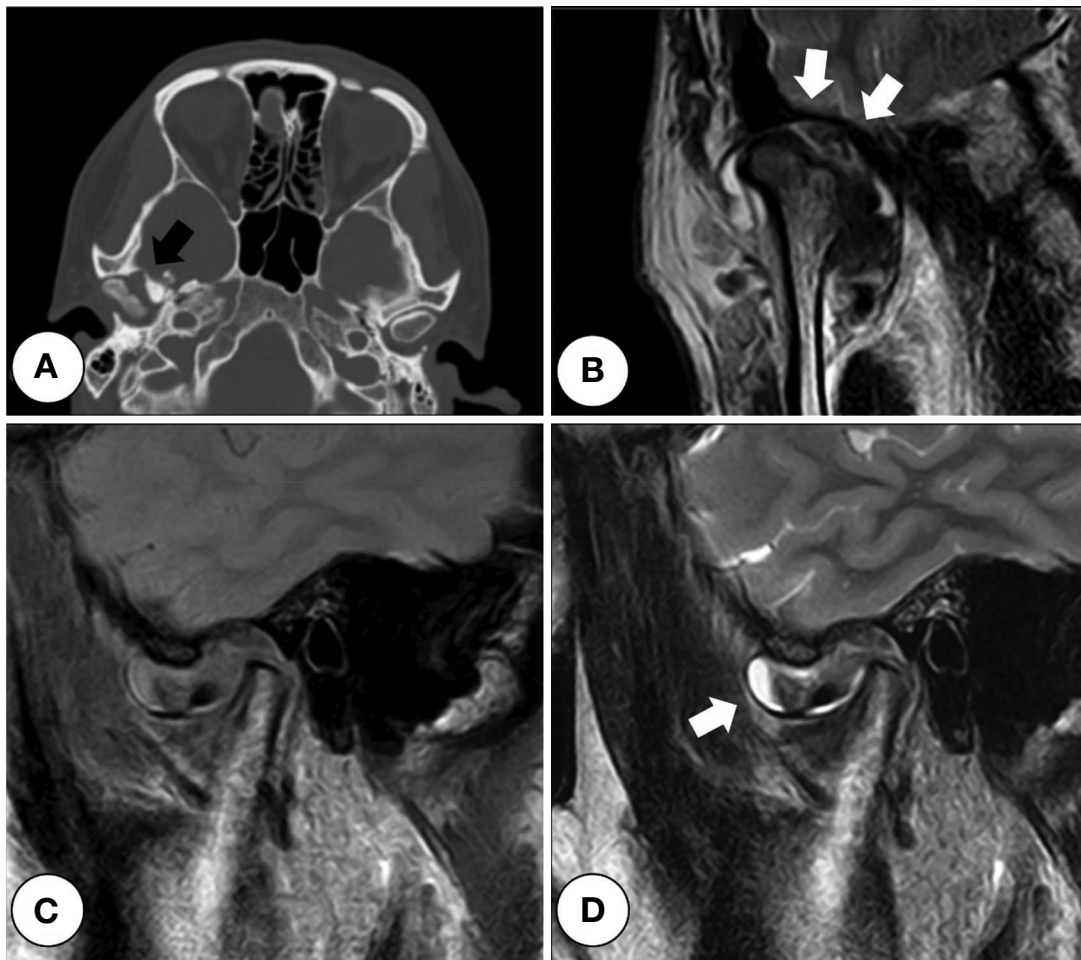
Imaging features of tenosynovial giant cell tumor (Case 2). A. Axial bone setting CT image shows compressive remodeling on the anterior slope of the articular fossa (black arrow). B. Coronal view of T2 weighted MR image presents low signal intensity (SI) with internal patchy-like heterogeneity on the right TMJ (white arrow). C, D. Sagittal MR images show anteriorly displaced disc and low SI tumor mass filling the superior joint space on T1 and T2 weighted images. Joint fluid collection (white arrow) is observed, which could suggest an inflammatory process regarding the etiology of the giant cell lesion.
